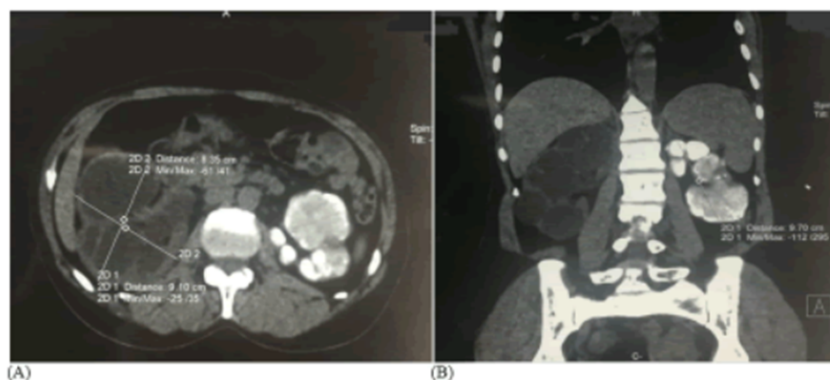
Figure 2: (a) Abdominal CT in axial section: several lobar parenchymal calcifications of all the calyces of the left kidney "mastic kidney", (b) Abdominal CT in coronal reconstruction: left kidney completely calcified putty".
